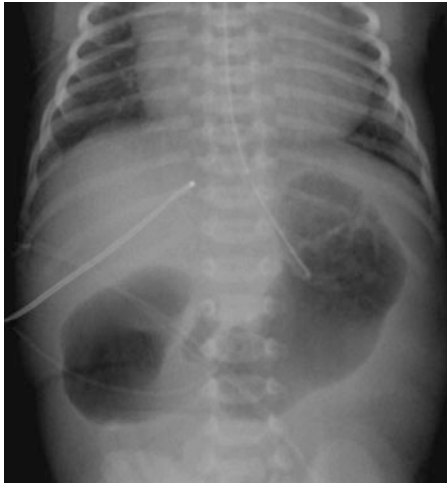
Double bubble sign demonstrated on plain radiograph. From Kuenzler K, Rothenberg S. Duodenal Atresia. In: Mattei P. Fundamentals of Pediatric Surgery. Springer, New York 2011 [11]. Reprinted with permission.
